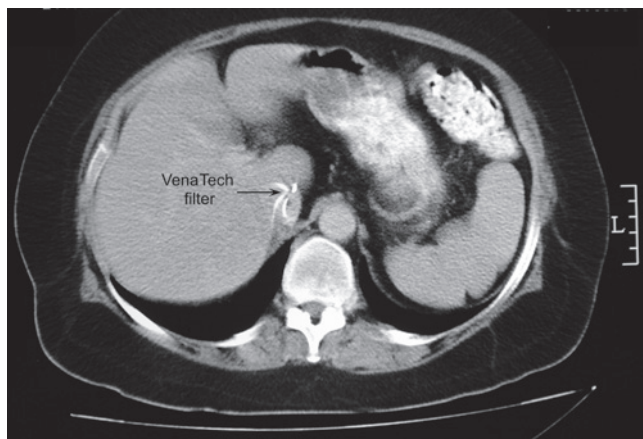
VenaTech filter with migration to the level of the intra-hepatic inferior vena cava demonstrated on CT scan.
